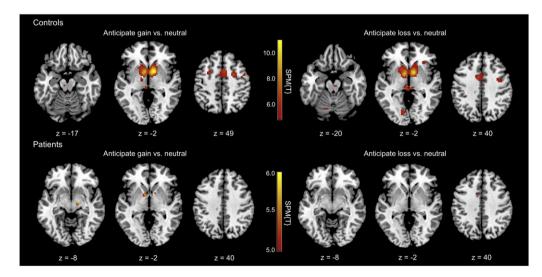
Functional MRI correlates of gain and loss anticipation in healthy controls and BPD patients. Top: In healthy controls, anticipation of both gains and losses was associated with activation of the midbrain (substantia nigra / ventral tegmental area, slice 1, 4), the VS/NAcc (slice 2, 5), and the dACC (slice 3, 6). Bottom: In BPD patients, midbrain and ventral striatal activation was observed during gain anticipation (slice 1, 2), but did not survive whole-brain FWE correction in the dACC (slice 3), while the reverse activation was observed during anticipation of losses (slices 4–6). All activation maps are thresholded at *p* < 0.05, whole-brain FWE corrected.
